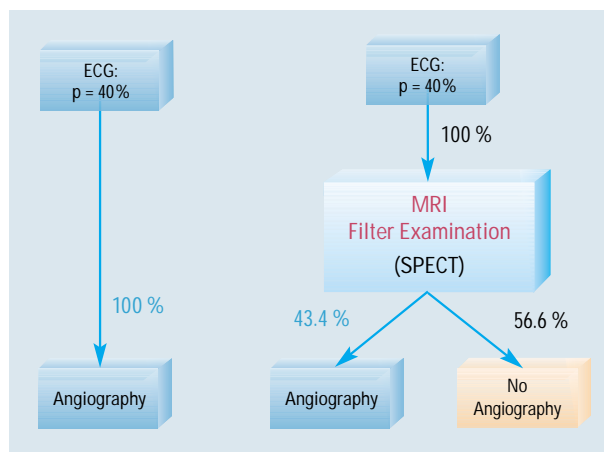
A comparison of the diagnosis scheme without and with a filter examination for patients who cannot be effectively examined via ultrasound. Whereas all of these patients normally undergo coronary angiography (as shown on the left), the cardiac MRI or SPECT filter
